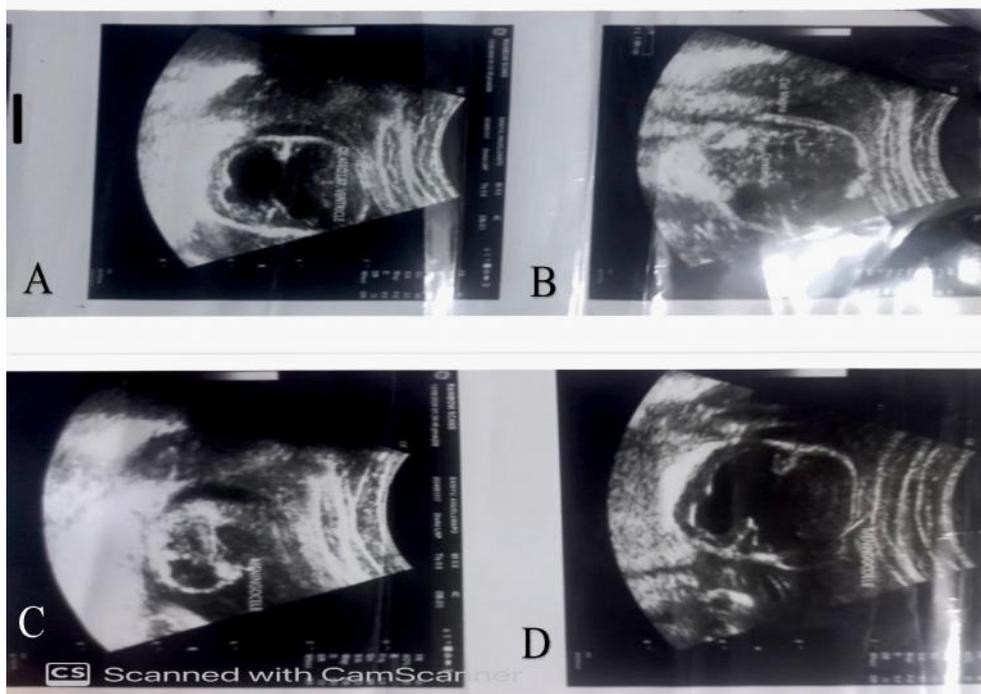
Antenatal fetal Ultrasound scan of the fetal head of the twin with anomaly showing A. Coronal view of the dilated lateral ventricles. B. Abnormally large Cerebellum and Cisterna magna. C. longitudinal plane of meningocele and D. transverse plane of meningocele
